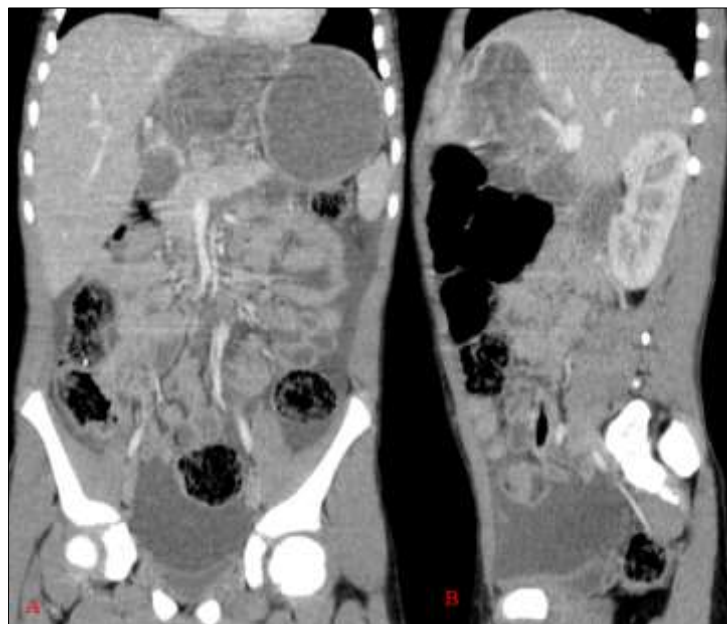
Contrast enhanced CT in portal phase Coronal (A) and Sagittal (B) section showing ruptured hydatid cyst of the liver with diffuse peritoneal fluid. No other
